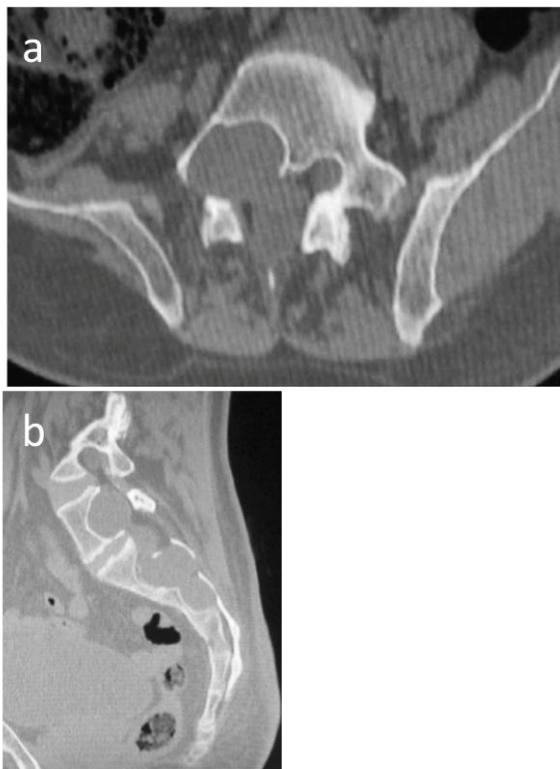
CT scan of the lumbo-sacral spine (in axial section – figure 2a , with sagittal reconstruction – figure 2b) revealed cystic lesions with widening of spinal canal and scalloping of the adjacent vertebral bodies from L5 to S4 vertebral levels.
